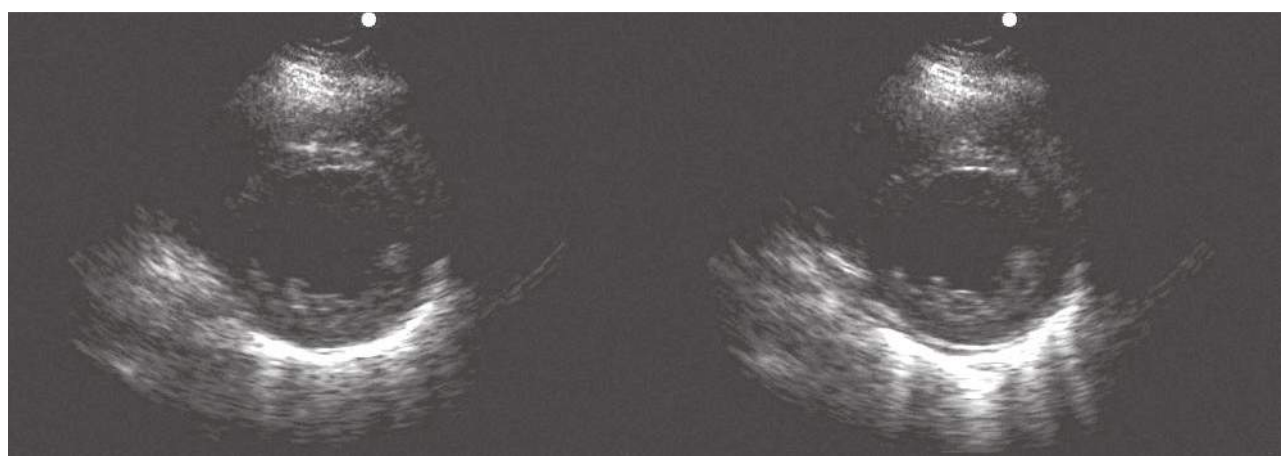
Parasternal short-axis view, dilated left ventricle (LV), poor ejection fraction. Parasternal short-axis view at the level of the papillary muscles showing poor LV systolic function. Note almost no change in LV cavity size or muscle wall thickness from (a) end diastole to (b) end systole.
